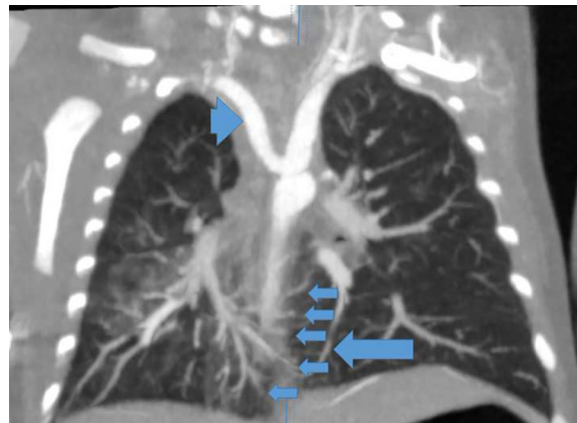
Coronal reformat chest CT angiography shows an aberrant right subclavian artery (long arrowhead), distal branches of the right pulmonary artery reaching the left lower lobe after crossing through the isthmus of the horseshoe lung (short arrows) and pulmonary veins from the left lower lobe draining into the left pulmonary venous system (long arrow).
